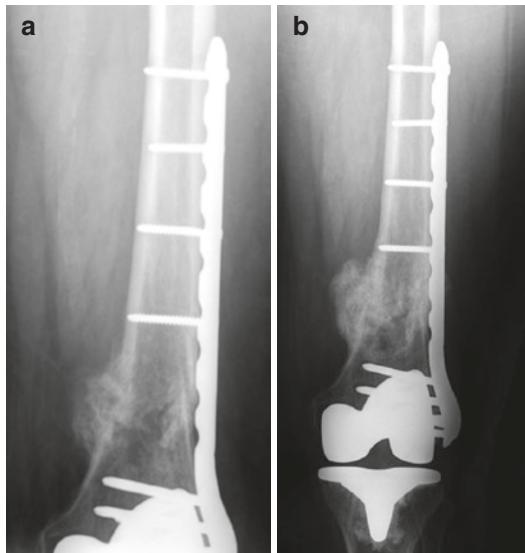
Anteroposterior (AP) postoperative radiographs showing distal femoral fracture at (a) 3 months and (b) 6 months with abundant callus formation
